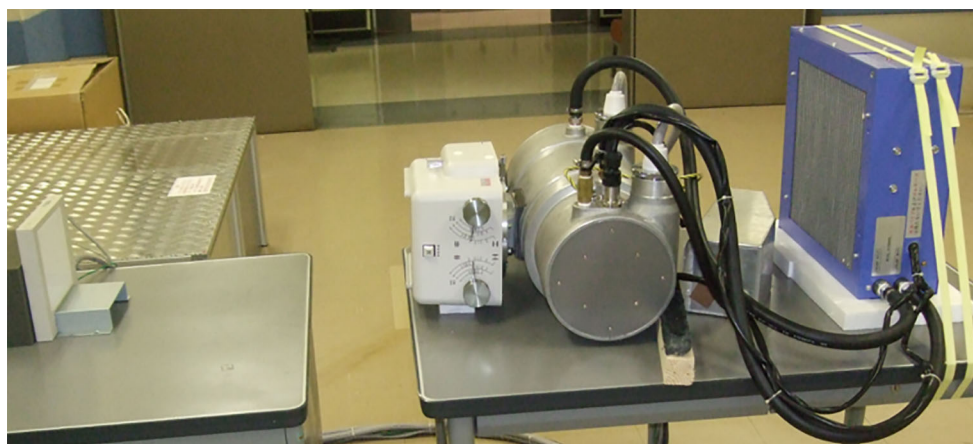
A new microangiographic X-ray system using a cerium anode. The cerium anode X-ray system is sufficiently small to be utilized in hospitals
